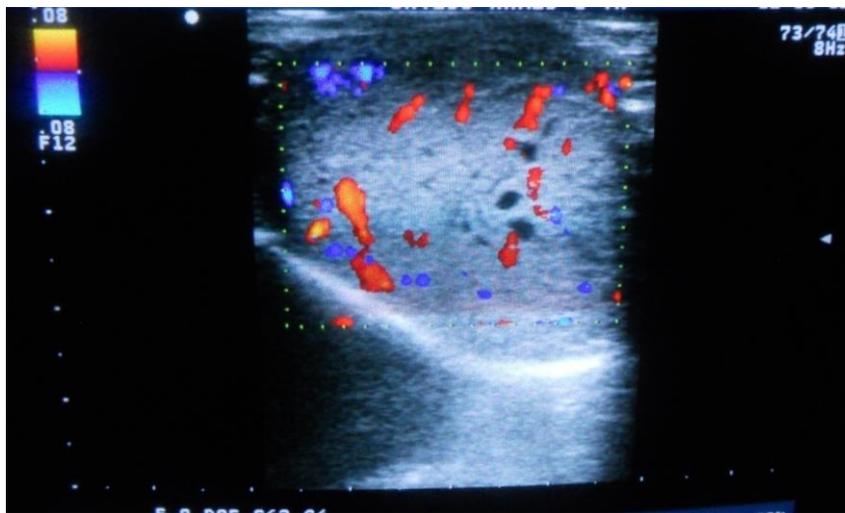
Color Doppler image shows increased intratesticular vascular flow
